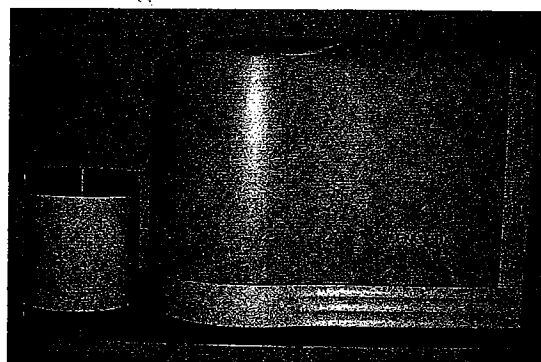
The Dentsply/Gendex DenOptix (Des Plaines, Illinois) is one of several currently marketed storage phosphor scanning systems used in dentistry for intraoral, panoramic and cephalometric radiography.
